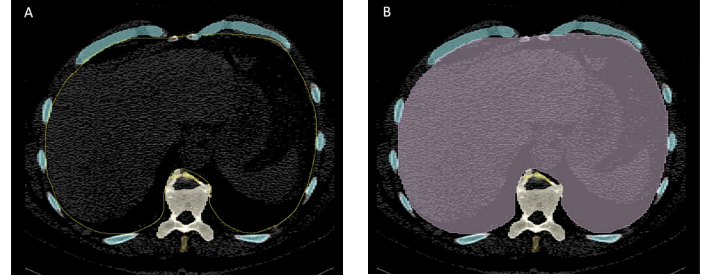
One of the axial slices in one patient's CT images. (A) shows the annotation line and (B) shows the area considered. Adapted from [12].
